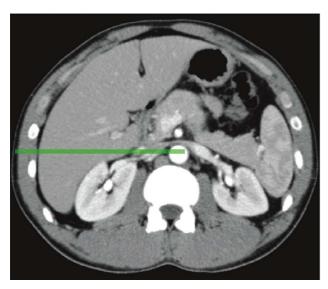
Inferior vena cava (IVC) and aorta may mimic free fluid in the right upper quadrant window. The axial CT image on the right shows the approximate scan plane that is captured. Notice that the hepatorenal space and right paracolic gutter are posterior and lateral to the IVC and aorta. Fanning and/or sliding the scan plane posteriorly will help to differentiate the IVC and aorta from free fluid in these spaces. Also, identifying the confluence of the hepatic vein inlet (HVI) with the IVC will confirm that the anechoic stripe is not free fluid but the IVC.
